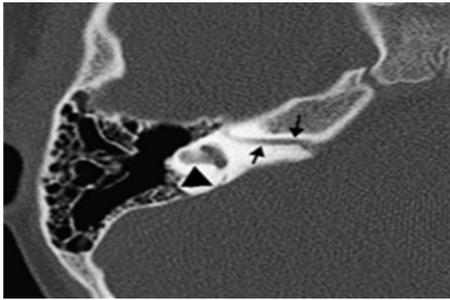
Refinement of the internal auditory canal. Right temporal CT scan axial cut showed narrowing (arrow). The patient also had a dysplastic vestibule and partially visible semicircularis canal (arrowhead)
